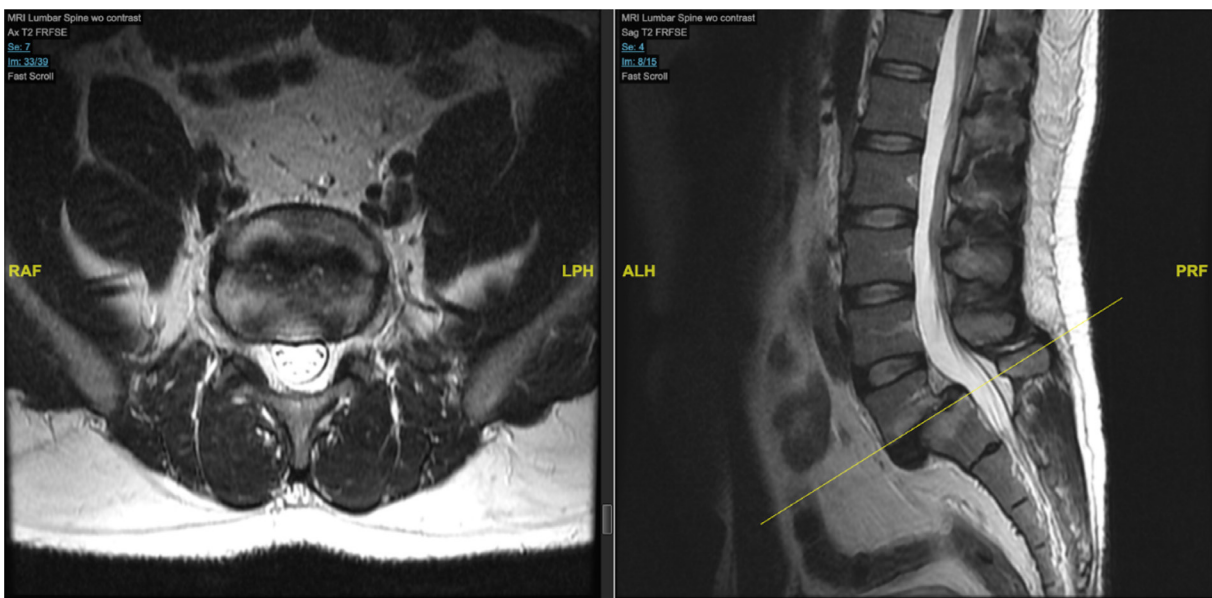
Preoperative axial (left) and sagittal magnetic resonance imaging (right) taken 2 weeks before the operation demonstrating grade III spondylolisthesis.
